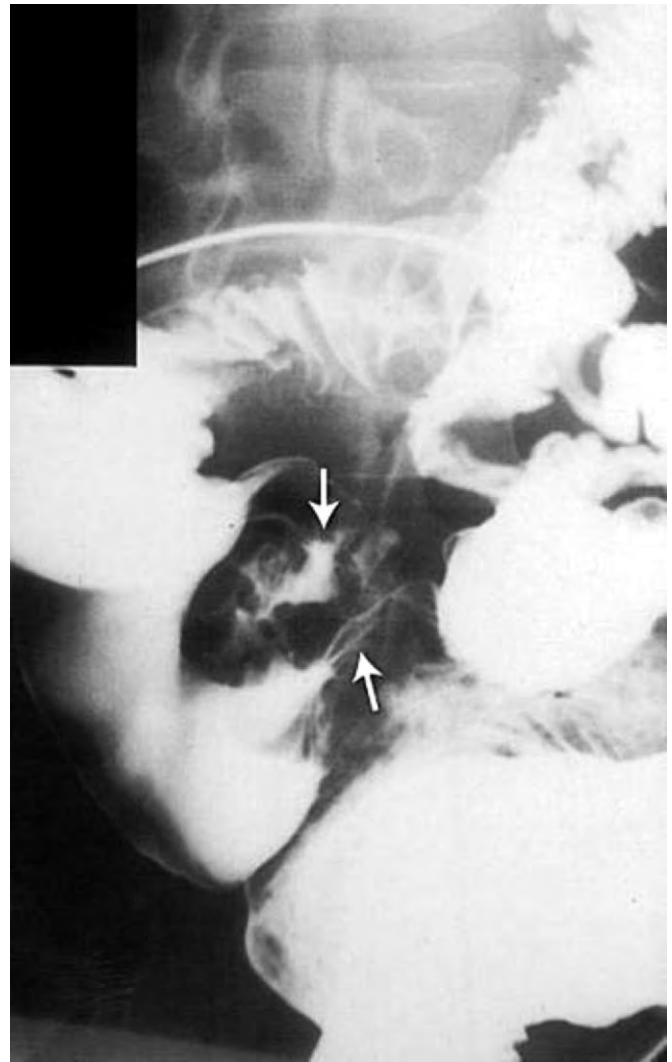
A barium radiograph of a carcinoid tumor of the terminal ileum demonstrates fibrosis with multiple filling defects and high-grade partial obstruction (*arrows*). (Courtesy of Melvyn H. Schreiber, M.D., The University of Texas Medical Branch.)
